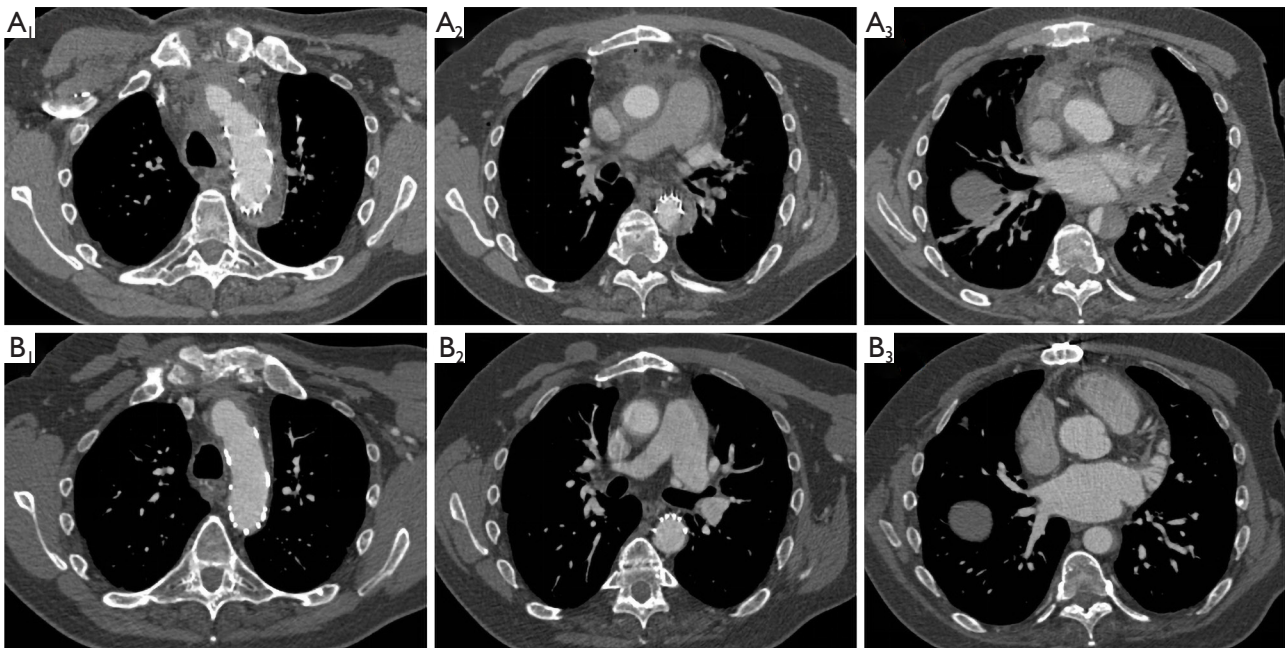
Computed tomographic angiography of a patient with chronic type A dissection 2 weeks (A1–A3) and 1 year (B1–B3) after surgery. The false lumen was obliterated with thrombus and the true lumen returned to normal at different levels. A1 and B1, around the frozen elephant trunk (FET); A2 and B2, at the distal end of FET; A3 and B3, extending to the diaphragmatic hiatus.
